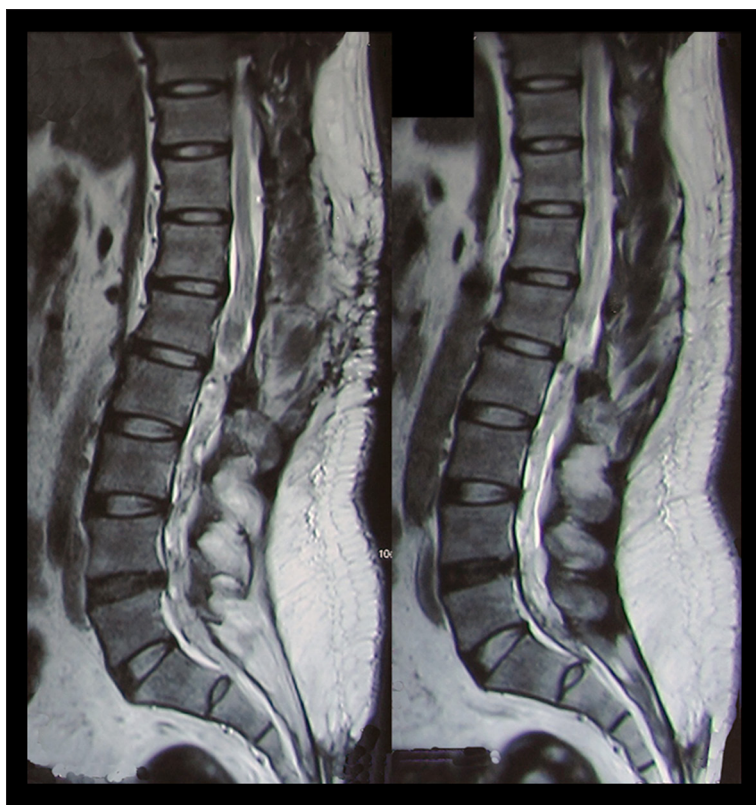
Magnetic resonance imaging at the final follow up (5 years after bone marrow derived mesenchymal stem cells injection) showing minimal changes of the myelomalacia and improvement of the transverse myelitis.
